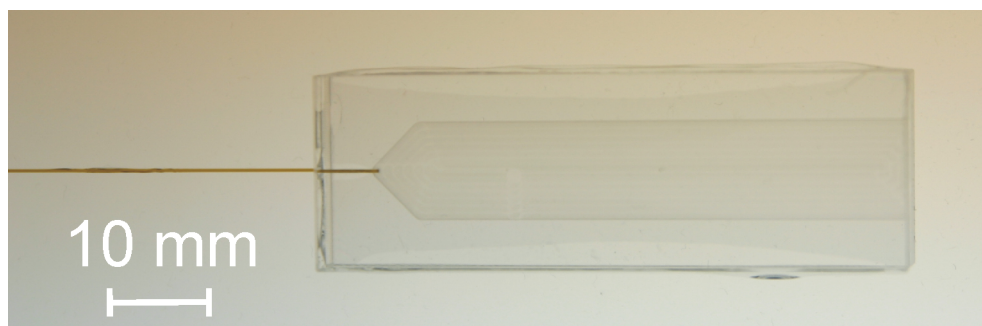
The 0.4 mm thick flat cell that was being used for the MRI experiments. Its outlet side on the right is open to allow the removal of bubbles etc.. The spread of the glue between the two acrylic glass blocks can be seen around the edges.
